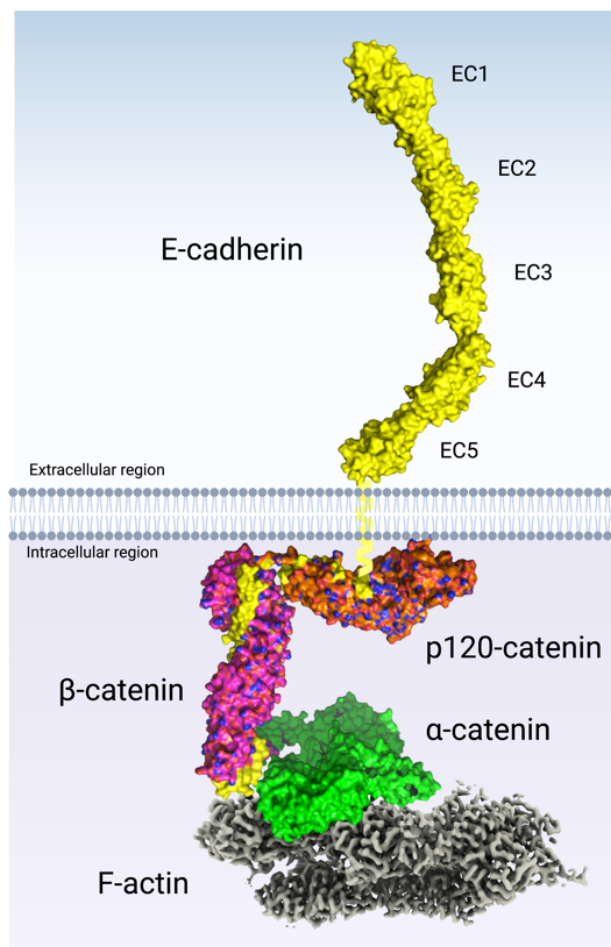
Model of the known cadherin-catenin complex and its connection to the actin cytoskeleton assembled from existing X-ray and cryo-EM structures.
